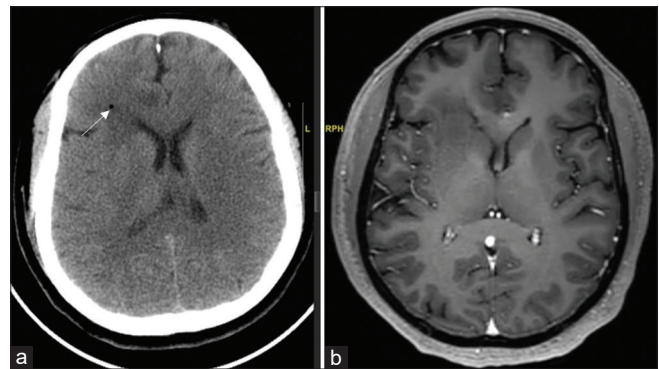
(a) Post procedure plain computed tomography showing right frontal periventricular location in relation to the caudate nucleus as an indirect evidence at corresponding cuts with white arrow indicating biopsy site. (b) In an index case of the right frontal glioma, preoperative contrast magnetic resonance imaging sequence.
